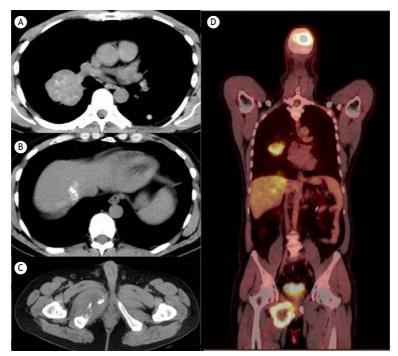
In A, axial chest CT image showing a mass in the right lung with stippled calcifications. Note the presence of another nodule in the left lung. Abdominal and pelvic CT demonstrated the presence of a calcified mass in the liver (B) and a lytic lesion in the right ischium (C). In D, PET/CT scan showed high fluorodeoxyglucose uptake in all lesions.
